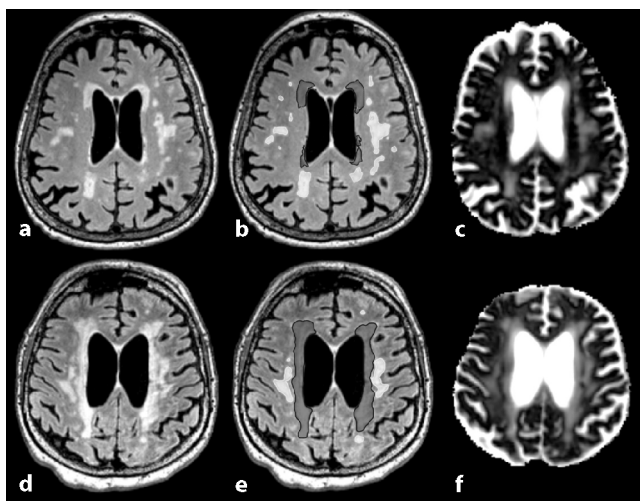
110 Axial FLAIR reformats in Patients without (a) and with imaging features of iNPH (d) with corresponding superimposed segmentations (b, e) divided into periventricular caps (dark grey) and deep white matter lesions (light grey). Related parametric V-CSF-maps are shown in c and f
